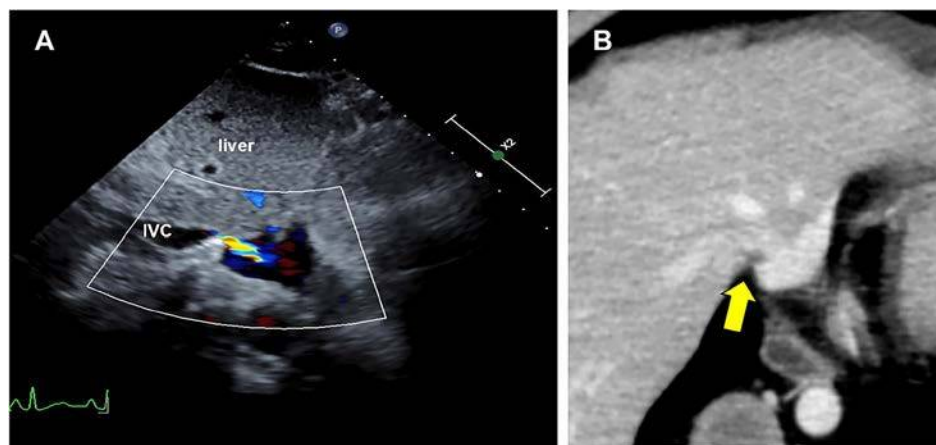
Cardiac ultrasound finding. A non-mobile, adhesive, hyperechoic lesion measuring 1.2 cm × 1.2 cm was found in the inferior vena cava (IVC) distal to the hepatic vein junction. Contrast-enhanced computed tomography finding. Low density adipose tissue with no contrast enhancement surrounding the inferior vena cava was observed protruding into the inferior vena cava at the level of the liver (yellow arrow).
